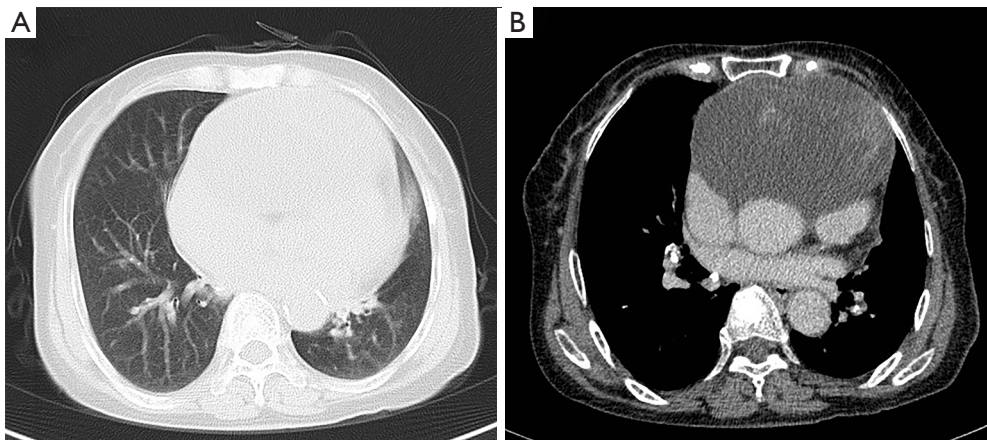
Patient's preoperative chest CT imaging. (A,B) A sharply demarcated, mostly solid mass in the anterior mediastinum on chest CT before surgical resection. The solid part showed significant inhomogeneous enhancement on the enhanced scan and was pressing the right ventricle and right atrium. CT, computed tomography.
